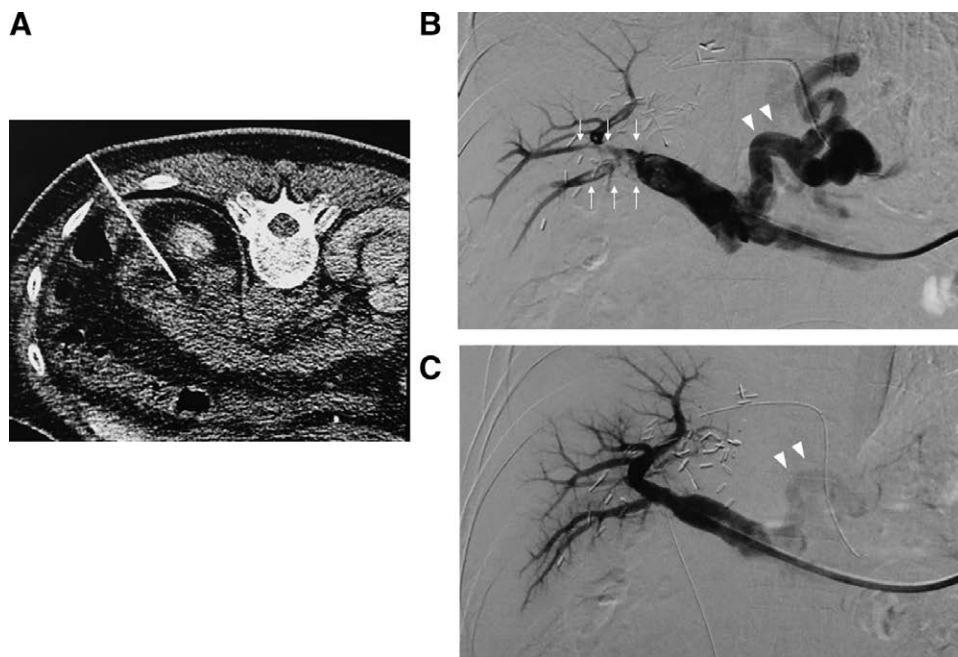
Portal vein thrombectomy by percutaneous intervention with direct puncture of the retropancreatic splenic vein. A, Trans-splenic venous access by direct puncture of the splenic vein under computed tomography guidance was applied in the prone position. B, Splenic venogram via trans-splenic venous access showed portal vein thrombosis (arrow) and strong visualization of the collateral vein via the left gastric vein (arrowhead). C, After the thrombectomy, the portal vein was reopened, and the collateral vessels were obscured (arrowhead).
